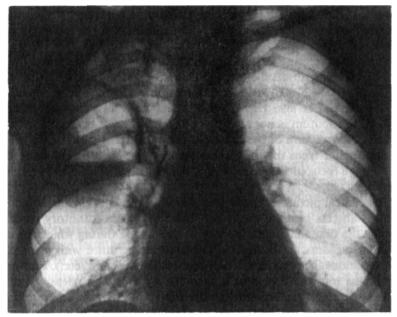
X-ray of abscess in the right lung.
